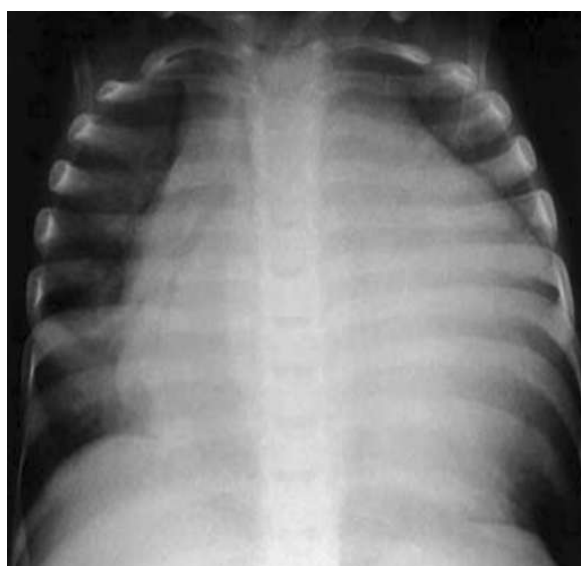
Frontal projection chest X-Ray showing cardiomegaly with clear lung fields.
